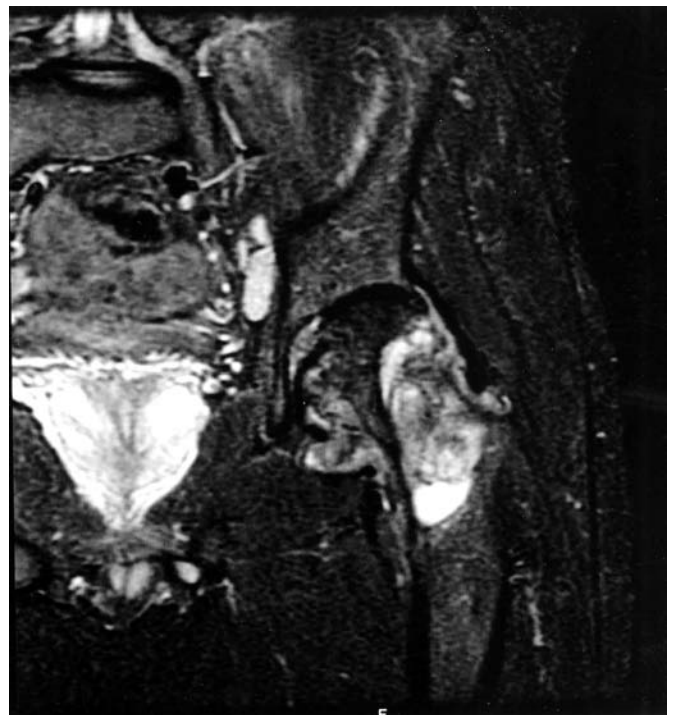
Coronal MRI of the left hip shows the lesion to be internally complex in the femoral neck and head with violation of the cortex (coronal non-contrast STIR image; TR/TI/TE 3717/140/42; 512 × 512; 2 NEX; 1.5 Tesla).
